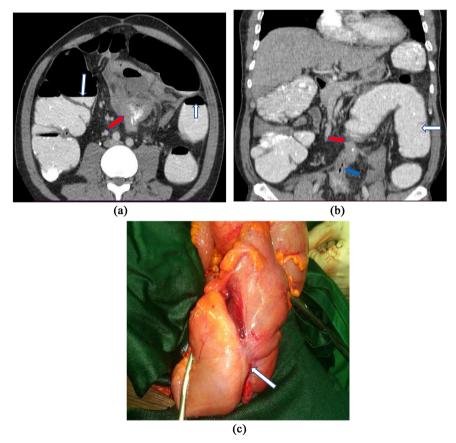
Obstruction on stenosing tumor of the sigmoid in a 71-year-old patient. (a) CT axial section showing colonic hydro aerial images (white arrows) and stenosing sigmoid tumor (red arrow). (b) CT frontal section showing the dilated colon (white arrow) and flat colon (blue arrow) on either side of a sigmoid tumor (red arrow). (c) Per-operative image of the stenosing tumor of the Sigmoid with obstruction (white arrow).
